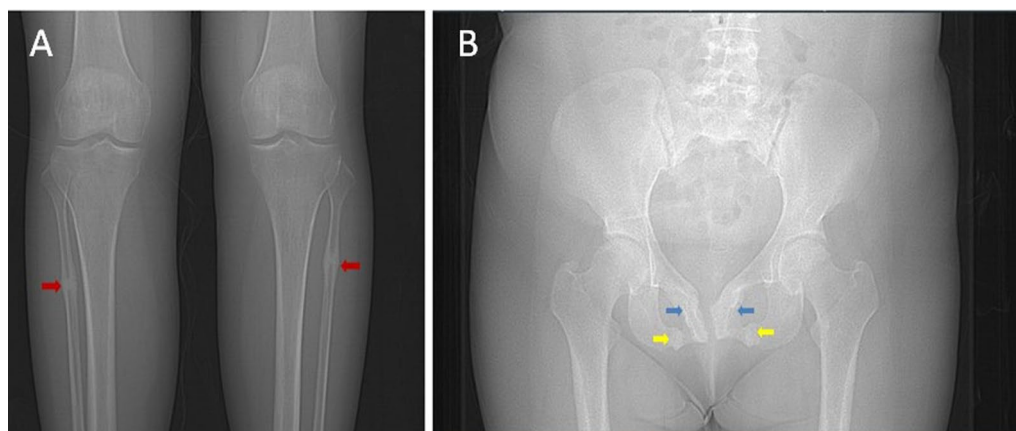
Multiple fracture radiographic imaging demonstrating irregular bone morphology with callus formation in the bilateral inferior pubic rami (B blue arrows), ischium (B yellow arrows), and proximal fibulae (A red arrows)
